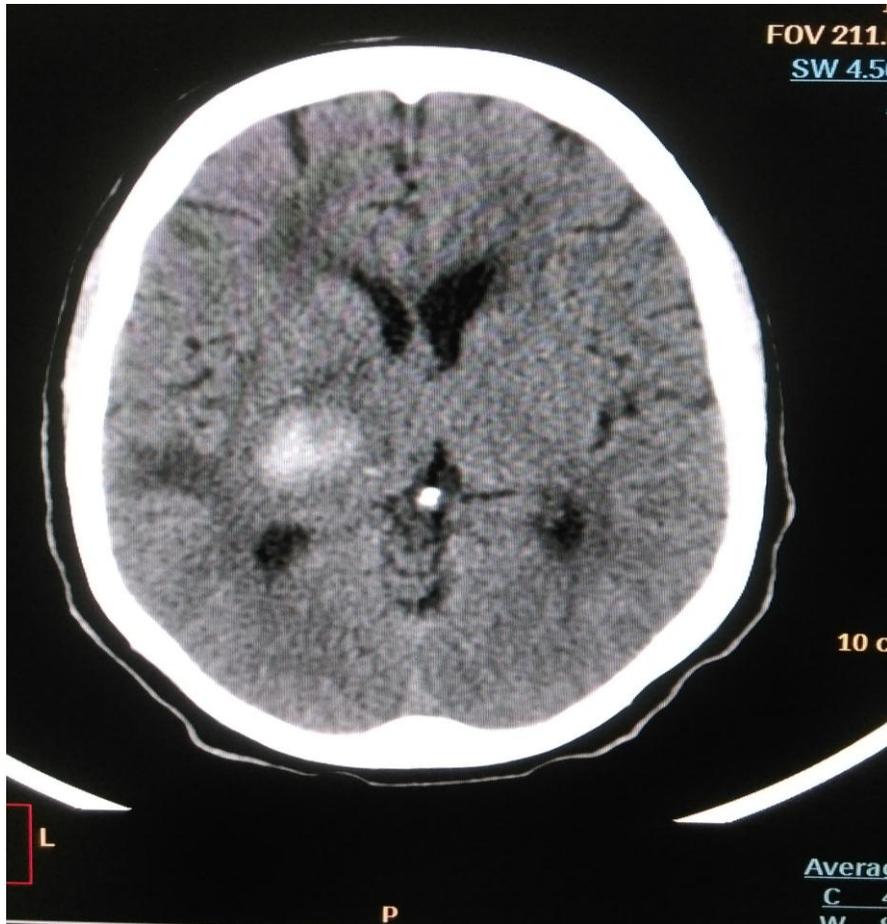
Non contrast cranial CT of the brain showing an oval shaped hyperdensity (hematoma) in the right basal ganglia (putamen) with compression of the adjacent lateral ventricle.
